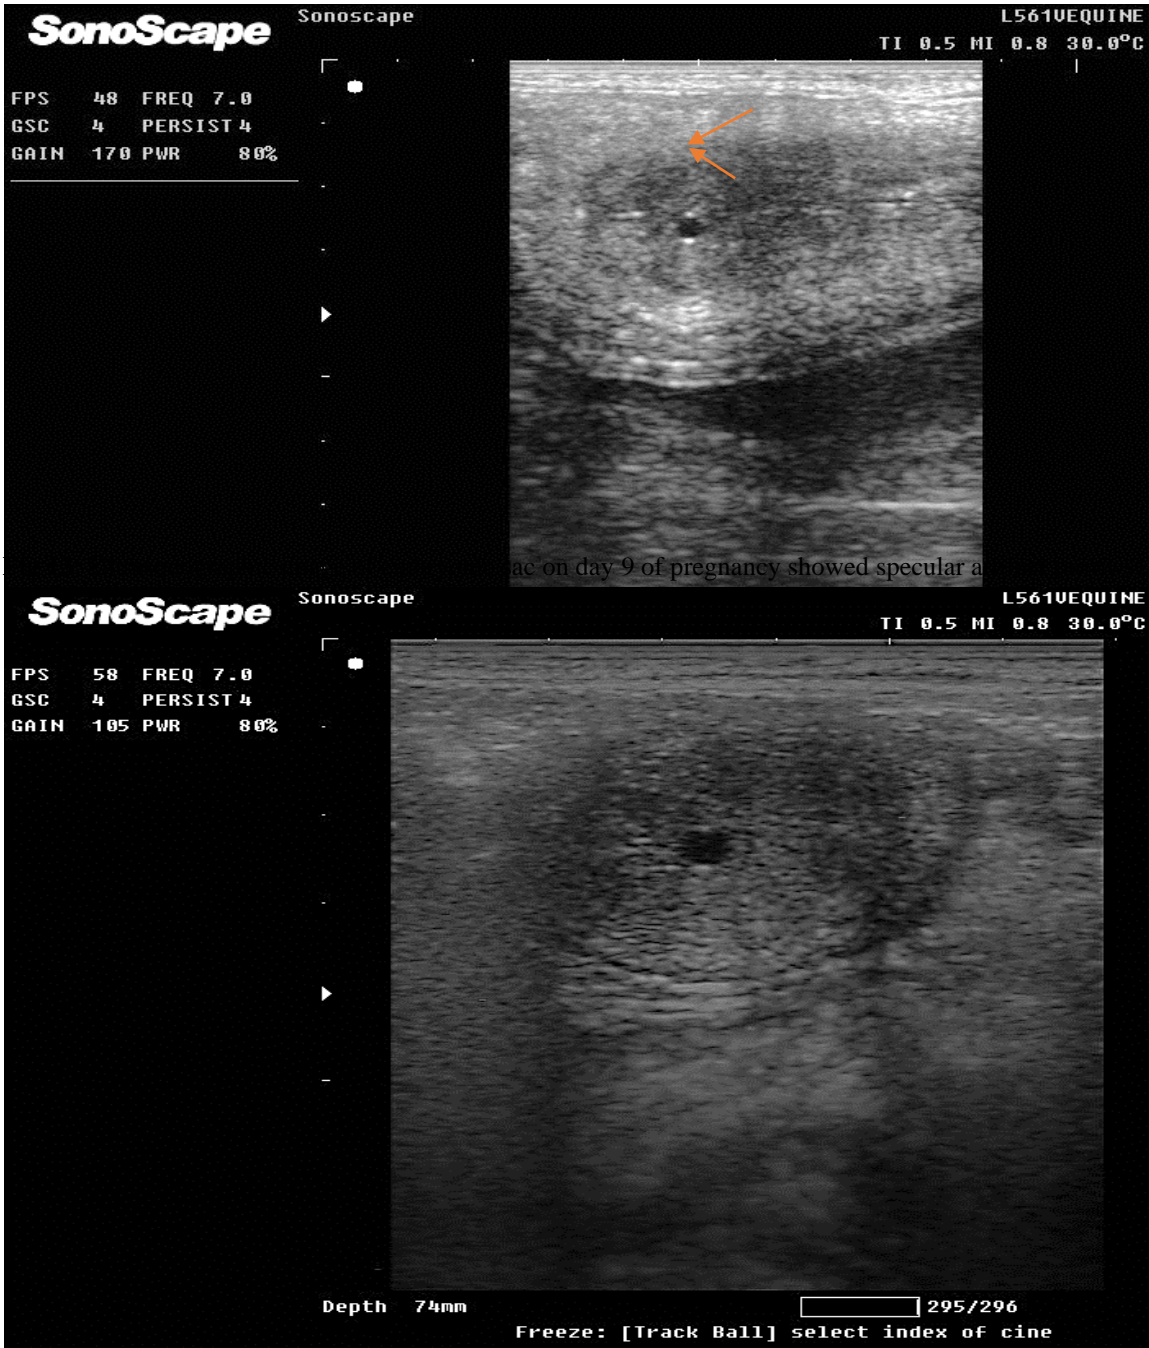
Ultrasonographic image of embryonic sac on day 10 of pregnancy
